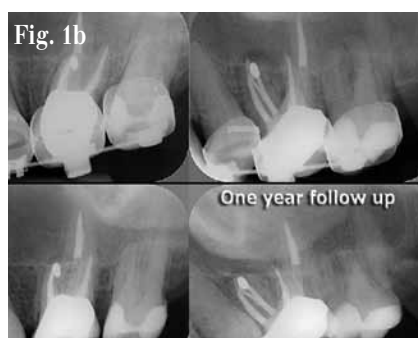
Previous endodontic therapy on tooth #2.6 (14) had failed; the clinician chose to correct the problem with a microsurgical procedure on the MB root. This procedure failed over time as well (sinus tract). Radiographic and clinical evidence demonstrate the developing apical lesion. The root canal system was re-accessed, the untreated canal identified, the entire system debrided, disinfected and after interim calcium hydroxide therapy, obturated. One year later, the lesion has healed. While the retrograde amalgam remained in the root end, its presumed ability to effectively seal a complex apical terminal configuration was ill-considered. Everything leaks in time; retreatment is always the first choice for resolution of an unsuccessful endodontic procedure, where possible.*
